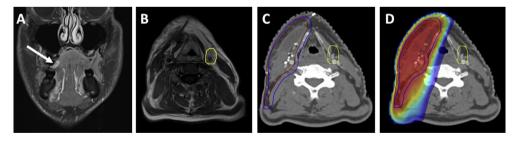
Example of type E recurrence in the nodal region (extraneous neck). Patient with a pT2pN1M0 squamous cell carcinoma of the right lateral tongue. Treatment was with partial glossectomy, free flap reconstruction and right selective neck dissection followed by adjuvant radiotherapy to the primary site and ipsilateral neck. Recurrence in the left neck occurred 8 months after the completion of treatment. (A) Diagnostic magnetic resonance imaging (MRI; T1 fat saturation with gadolinium enhancement) shows a well-lateralised lesion on the right tongue (white arrow). (B) MRI (T1W) at recurrence deformably co-registered to the planning computed tomography (CT) scan and left neck recurrence contoured (yellow). (C) Recurrence on planning CT (contoured on MRI deformably co-registered to planning CT). (D) Planning CT with plan dosimetry; clinical target volume in red, planning target volume in blue, left neck recurrence delineated by deformable co-registration of MRI in yellow.
